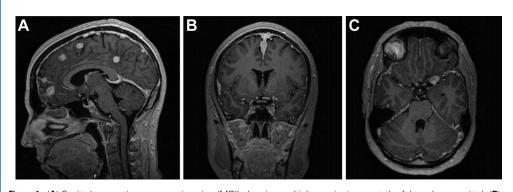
(A) Sagittal magnetic resonance imaging (MRI) showing multiple meningiomas at the falx and parasagittal. (B) Coronal MRI showing a meningioma at the falx and convexity. (C) Axial MRI showing a meningioma at the left sphenoid wing.
